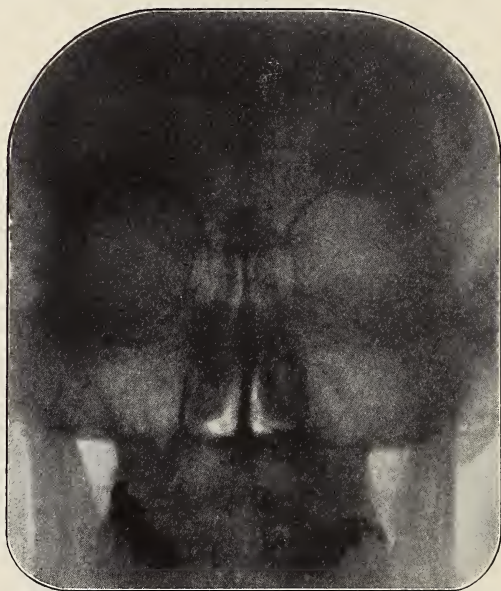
X-ray of head showing frontal and maxillary sinuses. The triangular area in the center of the picture is the nose. Compare with Figure 77.
